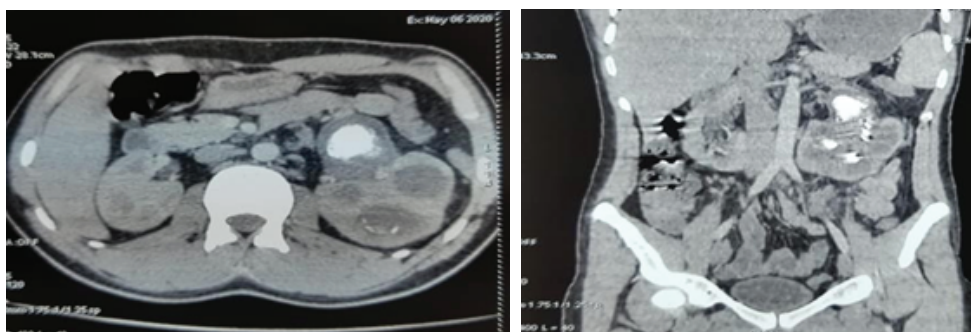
MRI showing acute obstructive pyelonephritis on horseshoe lithiasis kidneys
